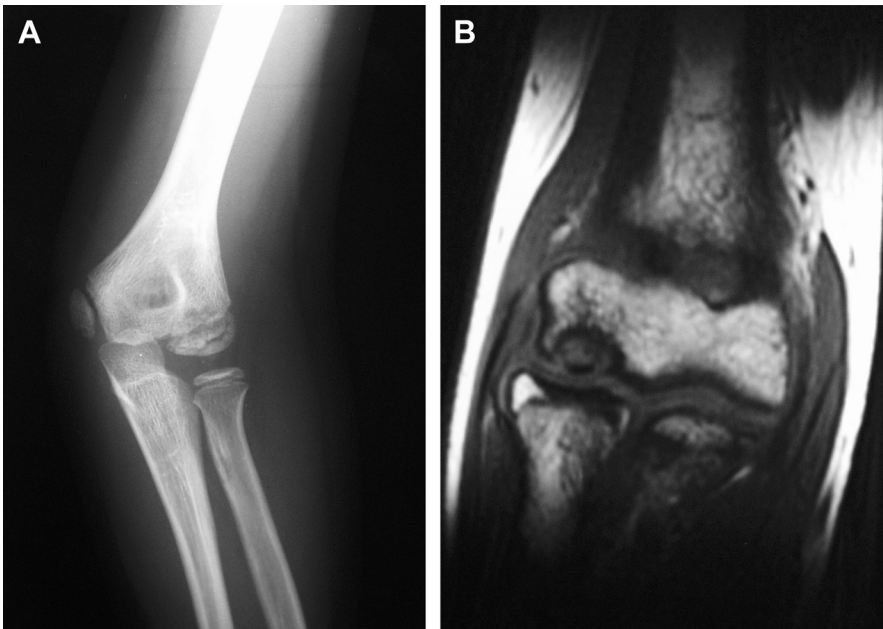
Radiograph of elbow capitellum Panner disease (A) in a younger patient and an MRI image of OCD (B) in an older patient. (Courtesy of San Diego Pediatric Orthopedics, San Diego, CA; with permission.)
